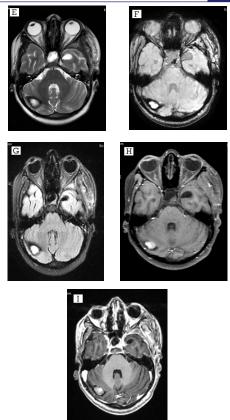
Axial T2-weighted (E), FLAIR (F), and gradient–(G) images show a left cerebellar hemisphere haemorrhage with mild mass effect and minimal adjacent oedema. (H& I) No enhancement seen in the post contrast T1-weighted MR image.
